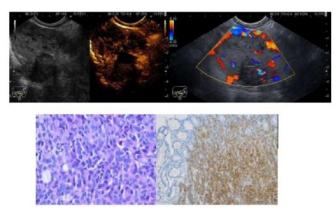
Advanced pancreatic neuroendocrine tumor (pNET) with multiple livers and lymph node mets, one of the lymph nodes being depicted as mixt hyper- and hypo-enhanced in the arterial phase (a), with intense color Doppler signals (b). Pathology showing a typical appearance of neuroendocrine tumor (col. HE, 400x) (c), G3 (Ki67>80%), with positive chromogranin and synaptophysin (200x) (d), both in the primary lesion but also in the secondary lesions (courtesy of Dr. Nona Bejinariu).
